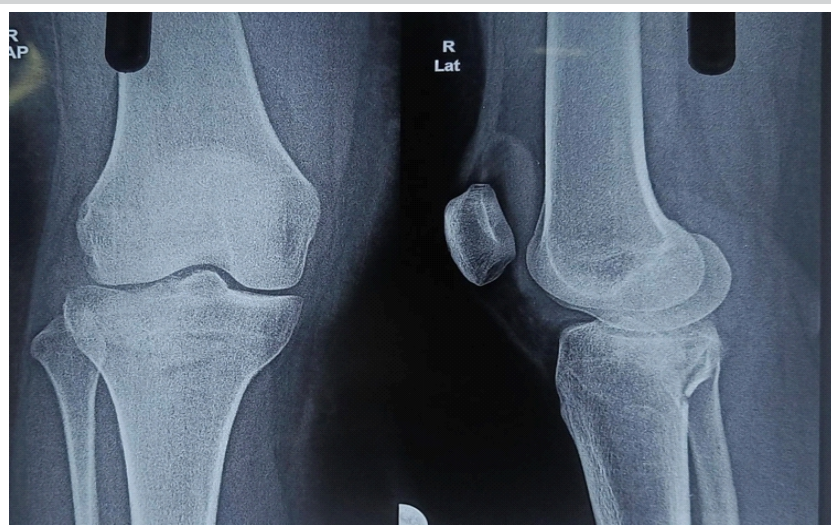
Plain radiograph of knee R showing depressed lateral and posterolateral tibial plateau fracture with large PCL avulsion fragment
